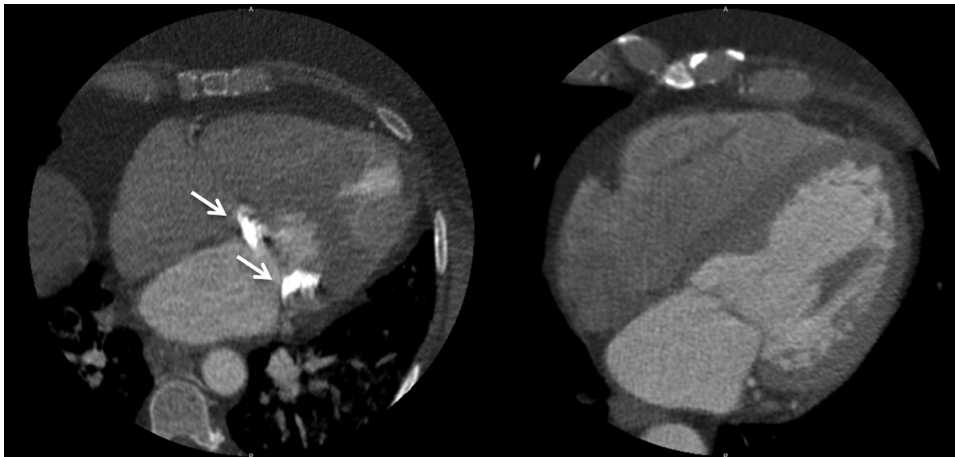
Coronary computed tomography angiography images in a patient with stage 3 chronic kidney disease and significant mitral valve calcium (*left panel, arrows*) and in a patient with stage 2 chronic kidney disease and no mitral valve calcium (*right panel*).
